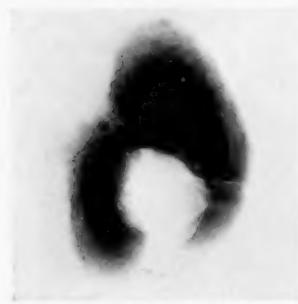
Case I. X-ray of stone showing lamination and area of slight density corresponding to bone.
